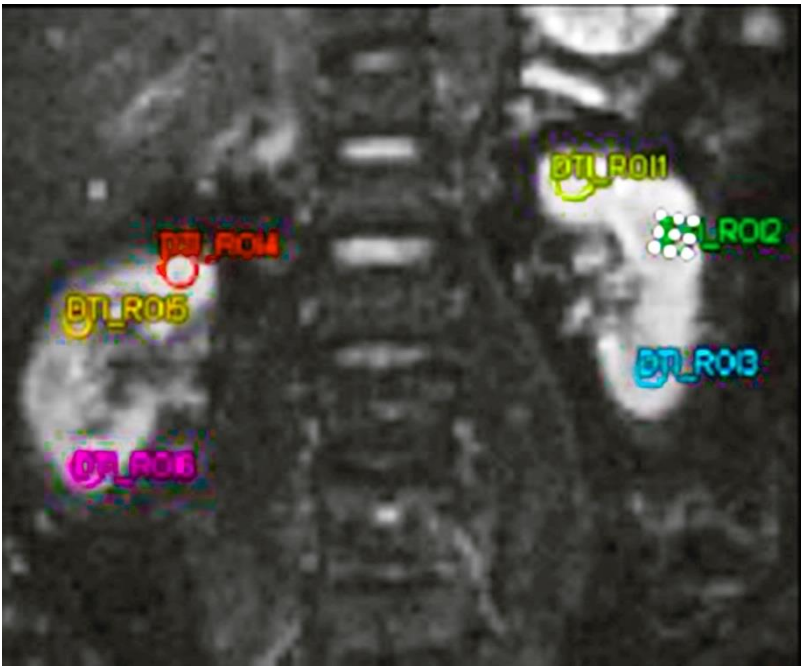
MRI DTI examination on a patient using 6 different region of interests. Abbreviations: MRI-DTI: Magnetic Resonance Imaging-Diffusion Tensor Imaging
